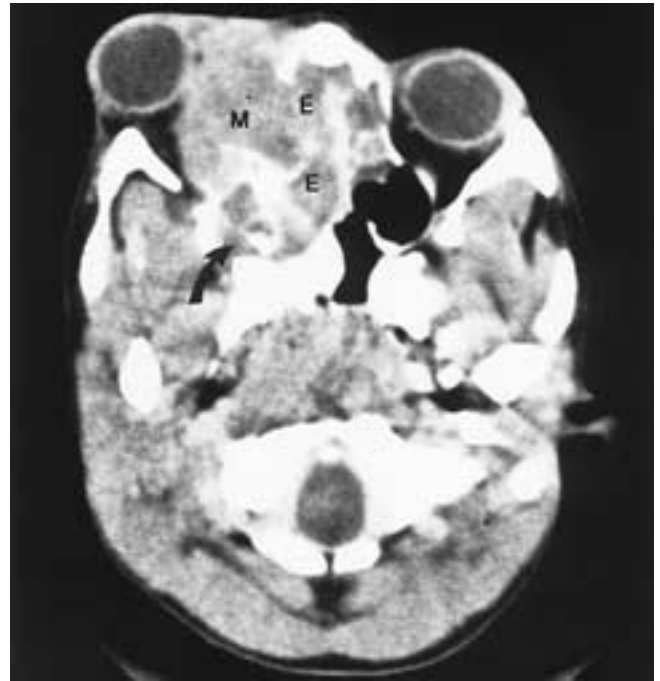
Rhabdomyosarcoma. Axial enhanced CT scan shows a large mass (*M*) in the right orbit extending into the right ethmoid air cells (*E*) and right infratemporal fossa (*arrow*).
